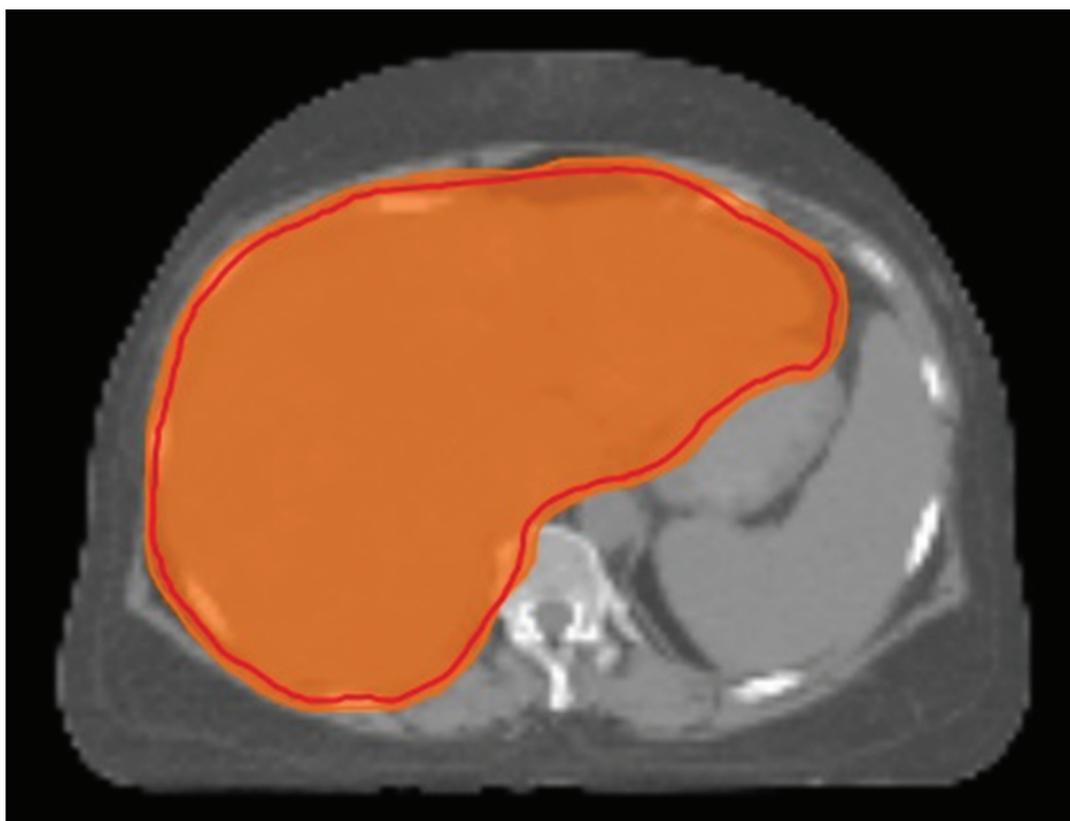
Axial computed tomography scan of abdomen showing 95% coverage of planning target volume of liver generated with helical tomotherapy planning system.
